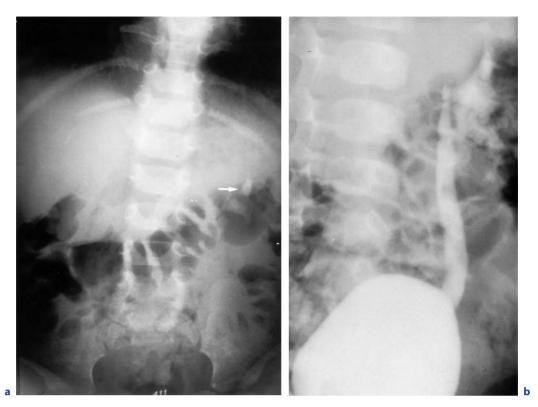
VUR and lithiasis. a Plain film of the abdomen showing the lithiasis. b VCU: left grade II VUR
